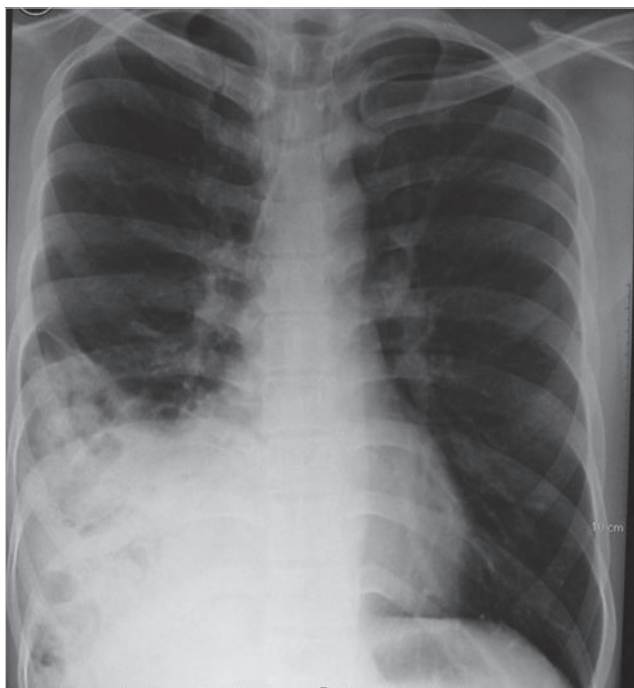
Simple chest X-ray showing a non-specific opacity at the right lower hemi-thorax.
